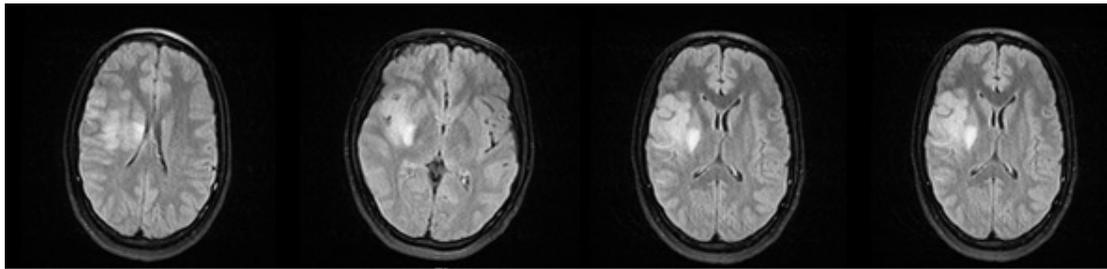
T2-FLAIR weight cerebral Magnetic Resonance image (MRI) of the brain without contrast, axial sections showing an incomplete right MCA flow void. There is a large middle right MCA distribution region of hyperintense diffusion signal.
